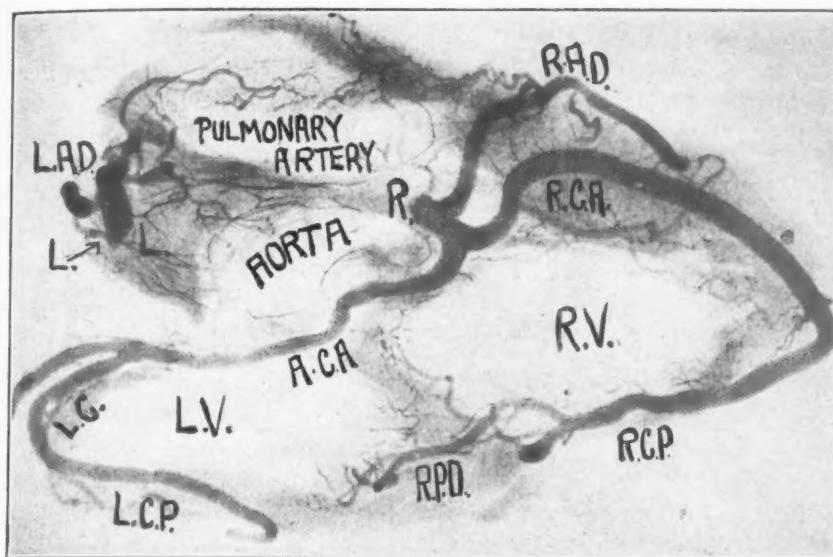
Roentgenogram of cross-section of injected heart near the base, showing the origin of the anomalous left circumflex coronary artery (A.C.A.), from the right coronary artery (R.C.A.). L.A.D., left anterior descending branch; L.C.P., posterior ventricular branches of the left circumflex coronary artery; R.C.P. and R.P.D., posterior ventricular branches of the right coronary artery; R.A.D., anterior descending branch of the right coronary artery.
